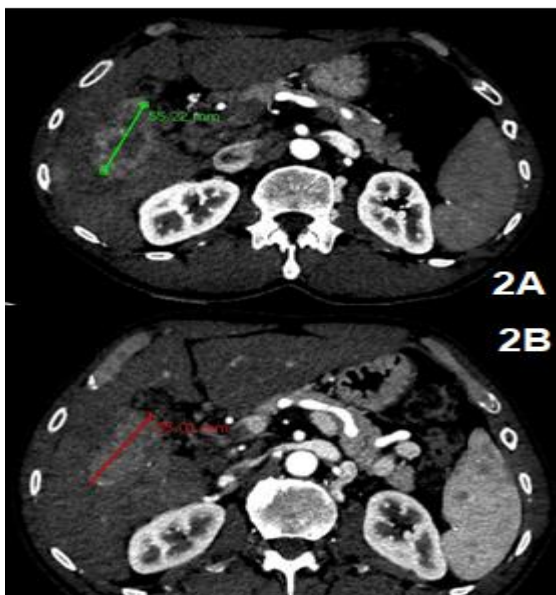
shows stable response of HCC in 42 years old female. 2A: Pre Sorafenib Axial slice through the triphasic CT scan in arterial phase shows arterialized HCC in segment V. 2B: Post sorafenib axial slice on the follow up triphasic CT scan at same level in arterial phaseshows no interval change in size of arterialized component.
